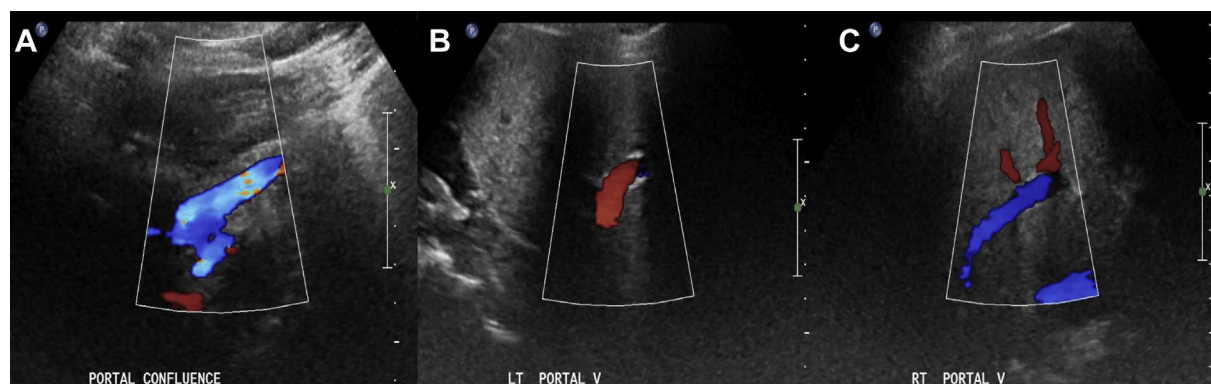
A, The 1-year post-treatment ultrasound image showing patency of superior mesenteric vein (SMV). B, Ultrasound image showing patency of left portal vein. C, Ultrasound image showing patency of right portal vein.
